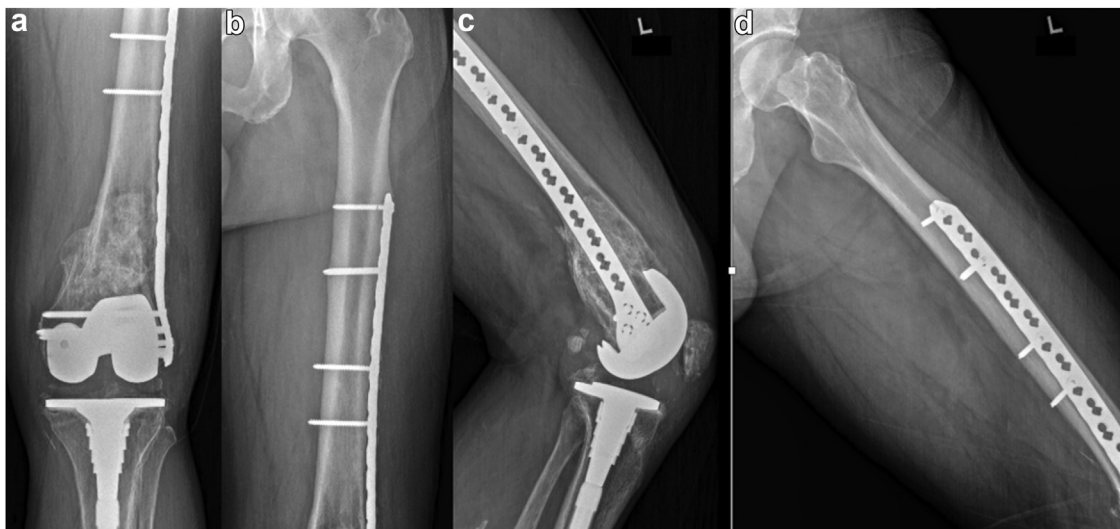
(a and b) AP and (c and d) lateral, 2.75-year postoperative radiographs of the left femur demonstrating abundant fracture callus and healing of the previous osteolytic lesion. Of note, the most proximal cortical screw is broken at the level of the threads with bony overgrowth at the most proximal aspect of the plate.
